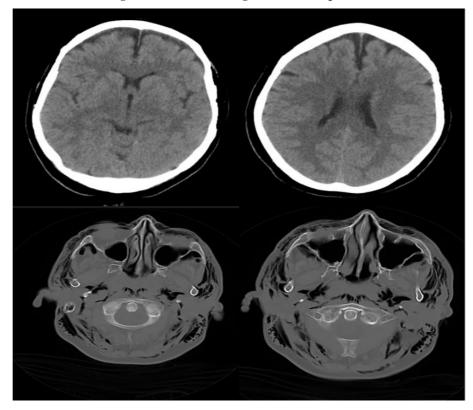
A brain CT scan of the patient showed the normality of the parenchyma and bone structures and extensive subcutaneous emphysema of the soft tissue of the head.
